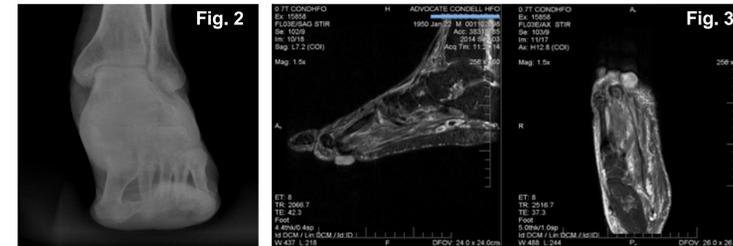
(Above) MRI demonstrating a well circumscribed lesion that extends to bone but does not invade bone
